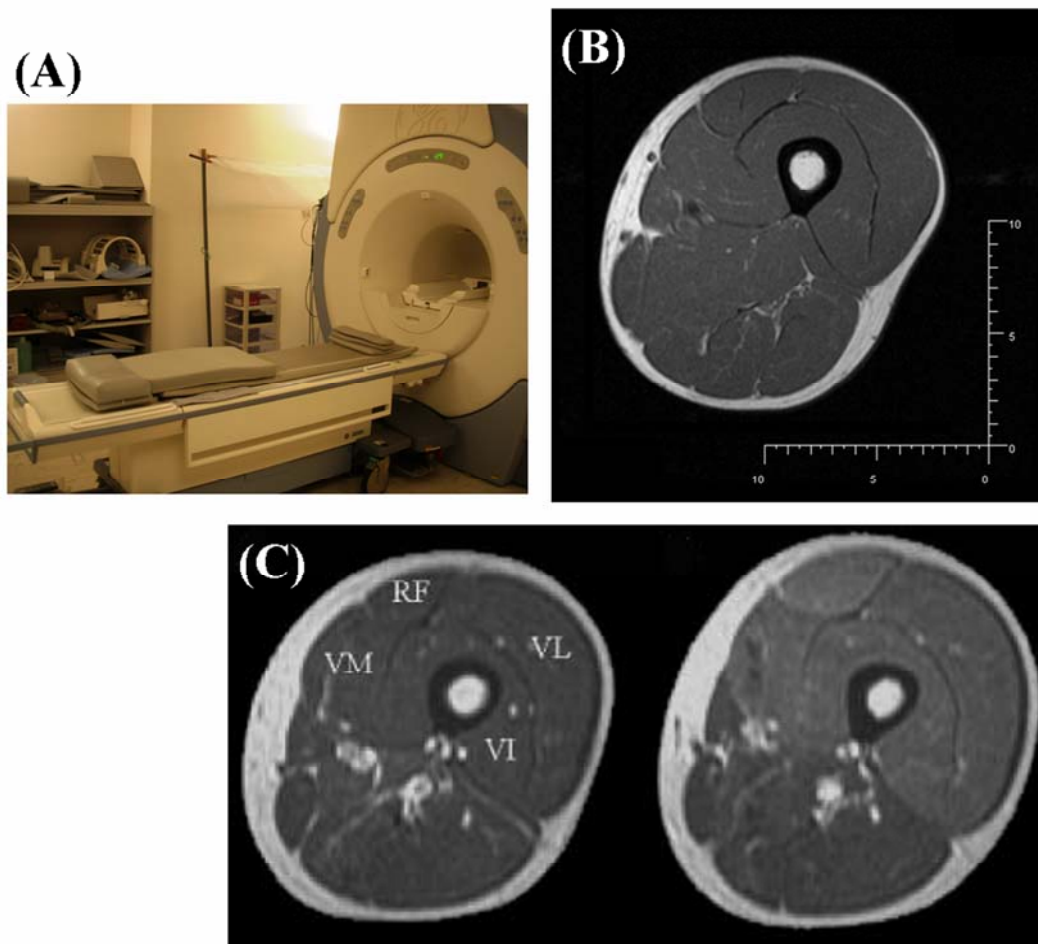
Magnetic resonance (MR) scanner and images. (A) A 1.5-Tesla MR scanner. (B) A T1-weighted spin echo image of the left thigh. (C) T2-weighted spin echo image of the left thigh before (left) and after (right) eccentric exercise of the knee extensor muscles (Prior et al. 2001). *RF* rectus femoris muscle, *VL* vastus lateralis muscle, *VM* vastus medialis muscle, *VI* vastus intermedius muscle.
